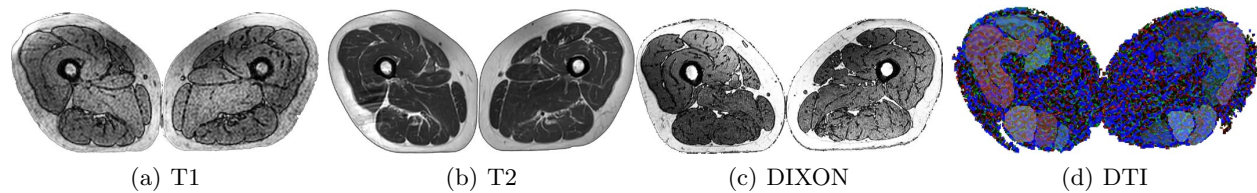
A cross-section of four MRI protocols for thigh muscle analysis. a) is T1, b) T2, c) DIXON protocol (out of phase) and d) DTI or diffusion Tensor model using weighted least squares which takes into account the noise characteristics of the MRI images to weight the DWI samples based on their intensity magnitude. Several metrics can be extracted from the Tensor model.
